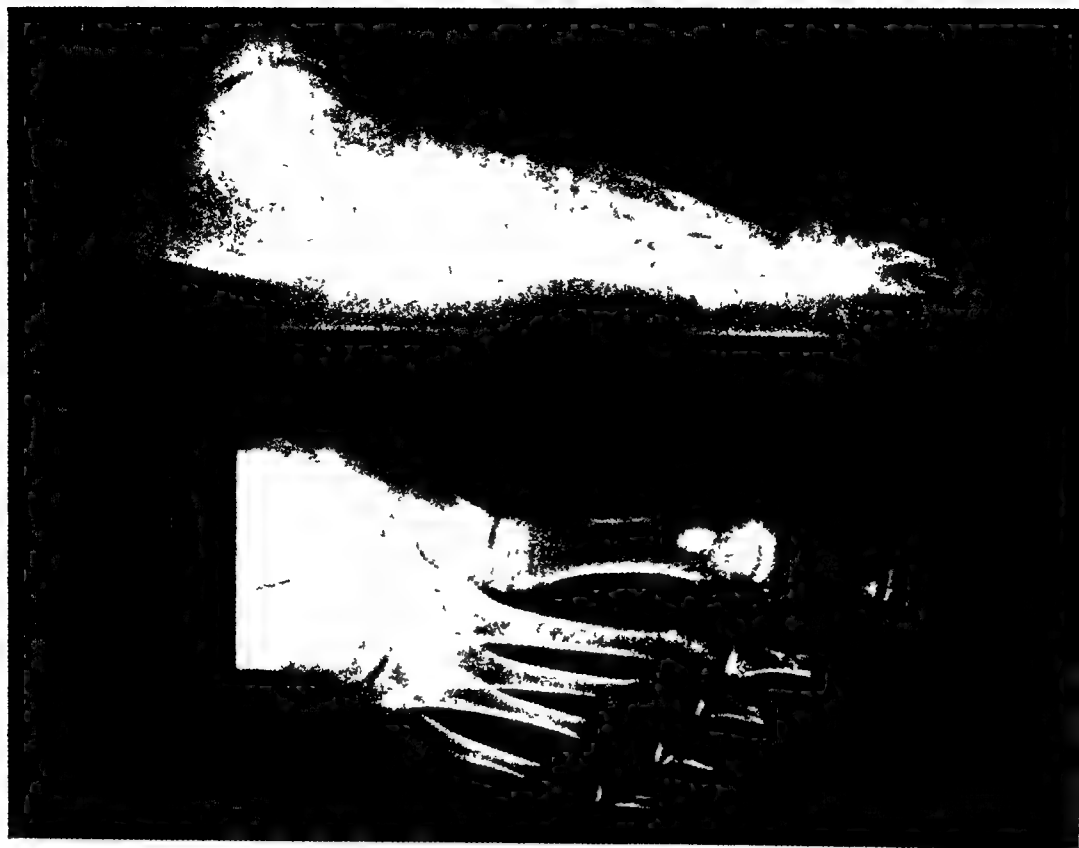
RADIOGRAPHIC FEATURES OF CONGENITAL PES PLANUS. (1) Plantigrade calcaneus (2) Anterior portion of calcaneus condensed and convex (3) Medial rotation of talus (4) Pseudo-normal mid-tarsal joint line. (5) Head of talus flattened (6) Tarsal arch spread. (7) Fifth metatarsal loosely articulated (8) Forefoot compensated into adduction
